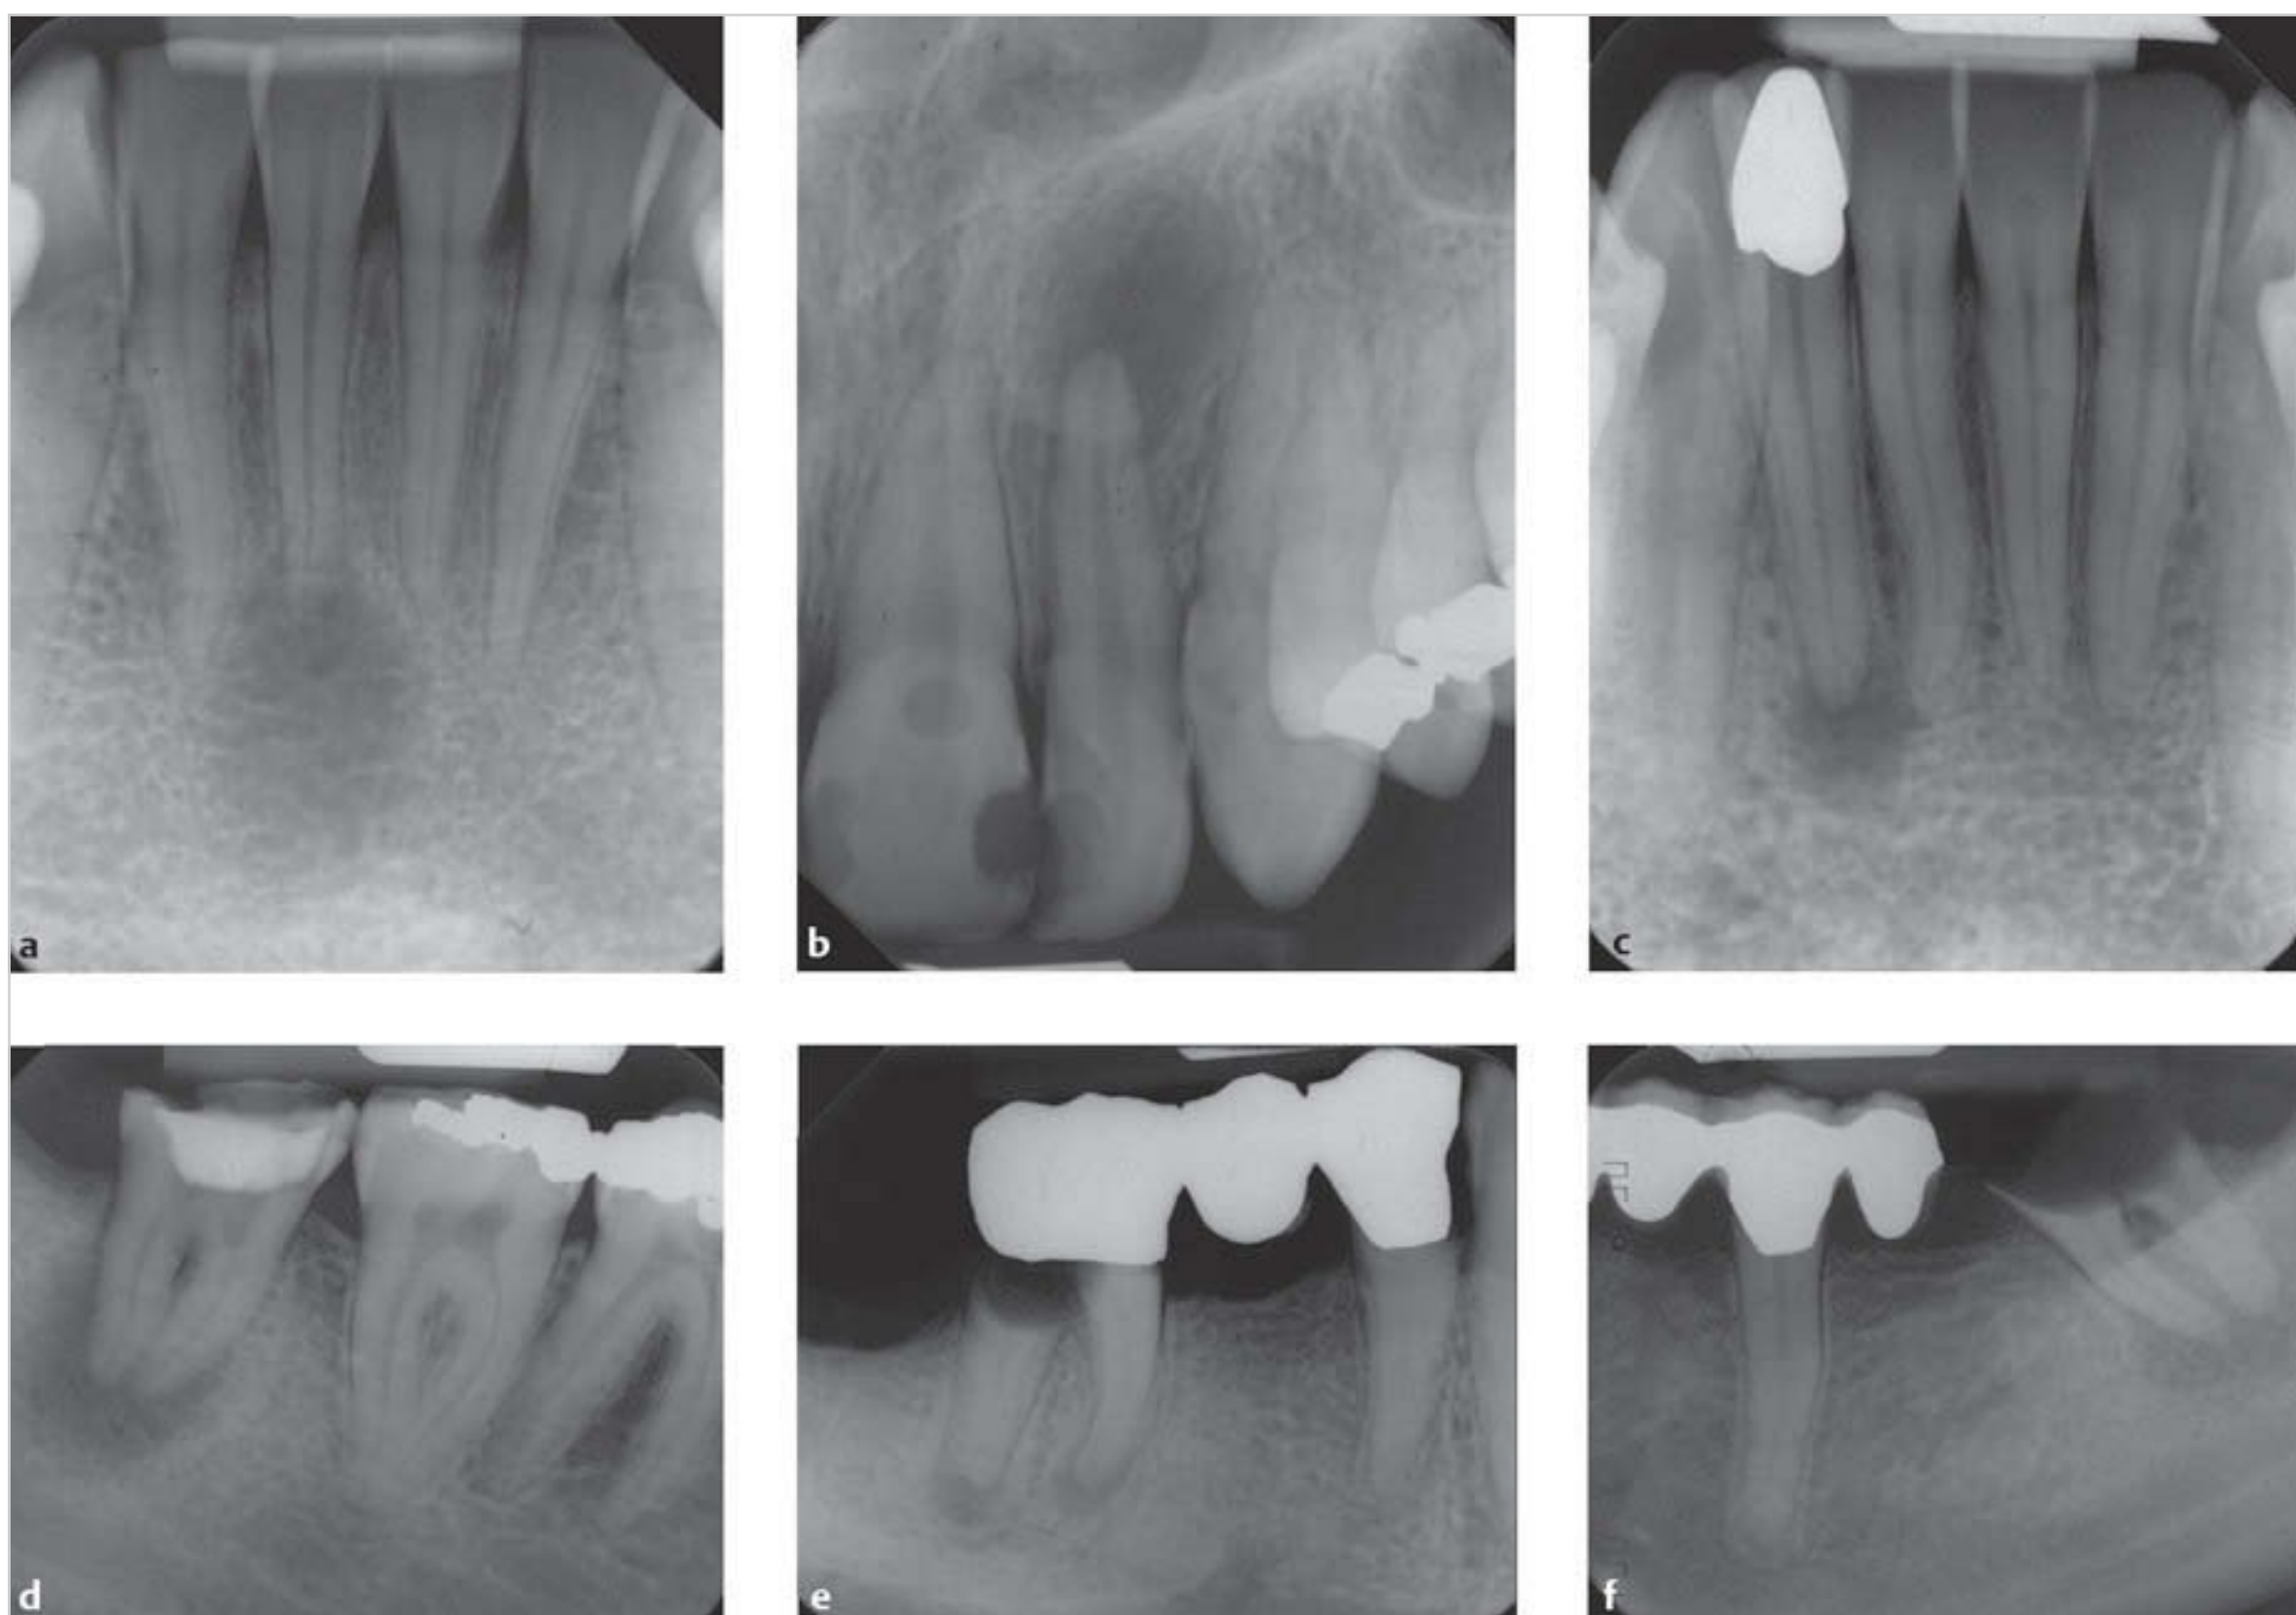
Diffuse periapical radiolucencies.
